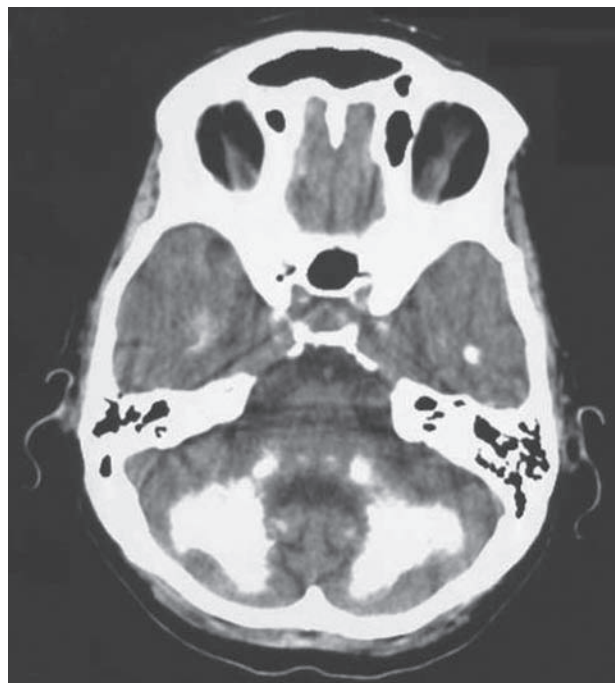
Hypoparathyroidism. Cerebellar calcification on CT brain scan.
